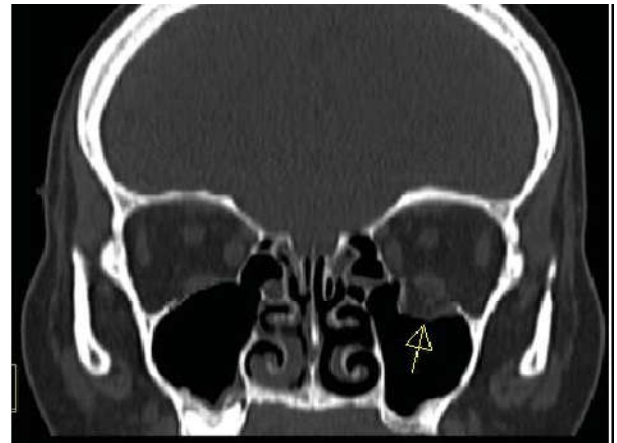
Coronal CT scan showing Entrapment of Inferior Rectus Muscle
